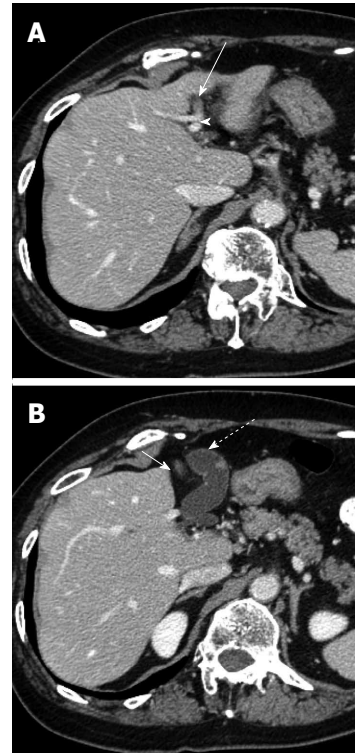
Computed tomography examination reveals a left-sided gallbladder. A: The round ligament (arrow) is connected to the left portal umbilical portion (arrow head); B: The gallbladder (dotted arrow) is located to the left side of the round ligament (arrow) and the middle hepatic vein, and attached to the left lateral section of the liver.
